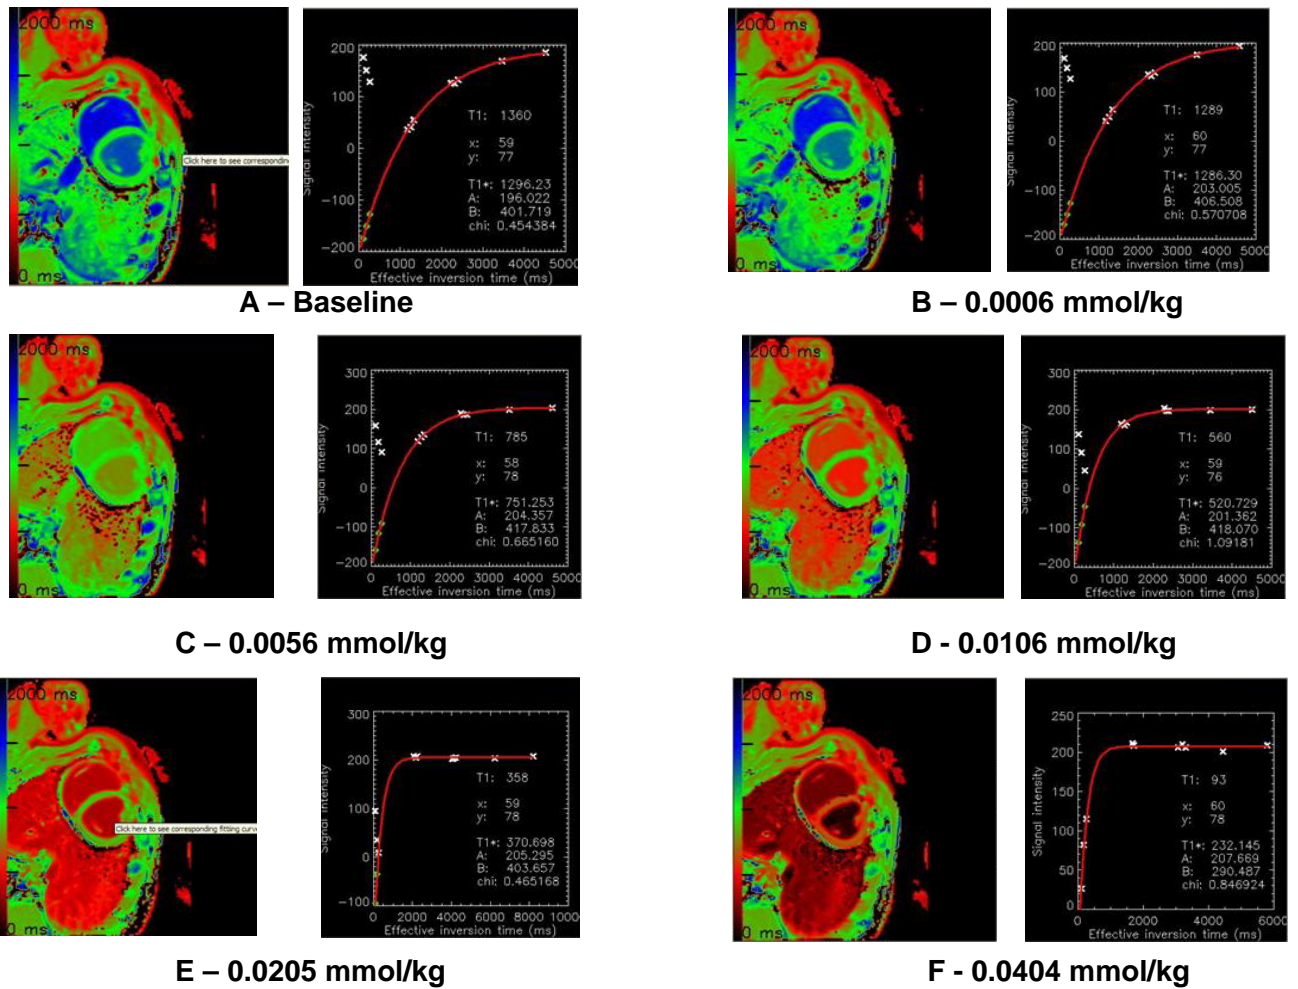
For one subject, MRI images and corresponding T1 relaxation curve for blood is shown for baseline (no contrast) and for accumulative doses of *Gadolunate*.
